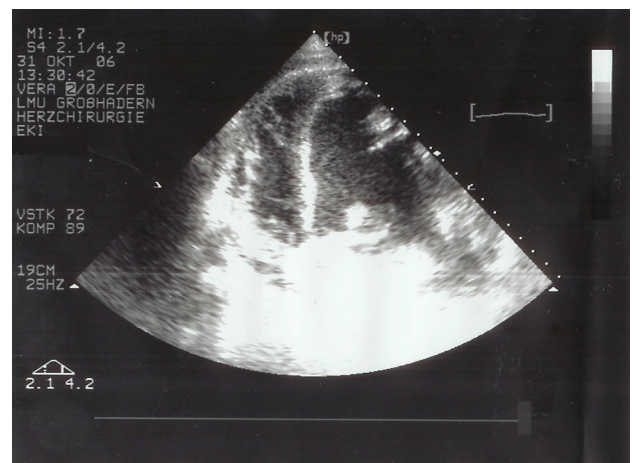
Echocardiogram documenting the intracavitary position of the left ventricular cannula.
